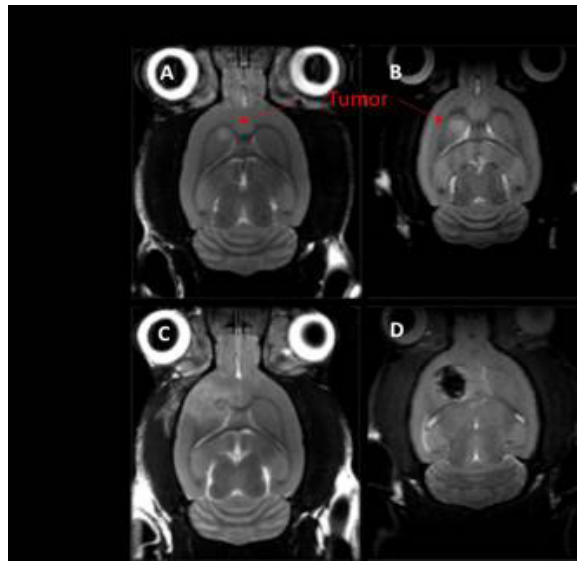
T2-weighted images of MB-facilitated ablation and PFB PSNE-facilitated ablation.
